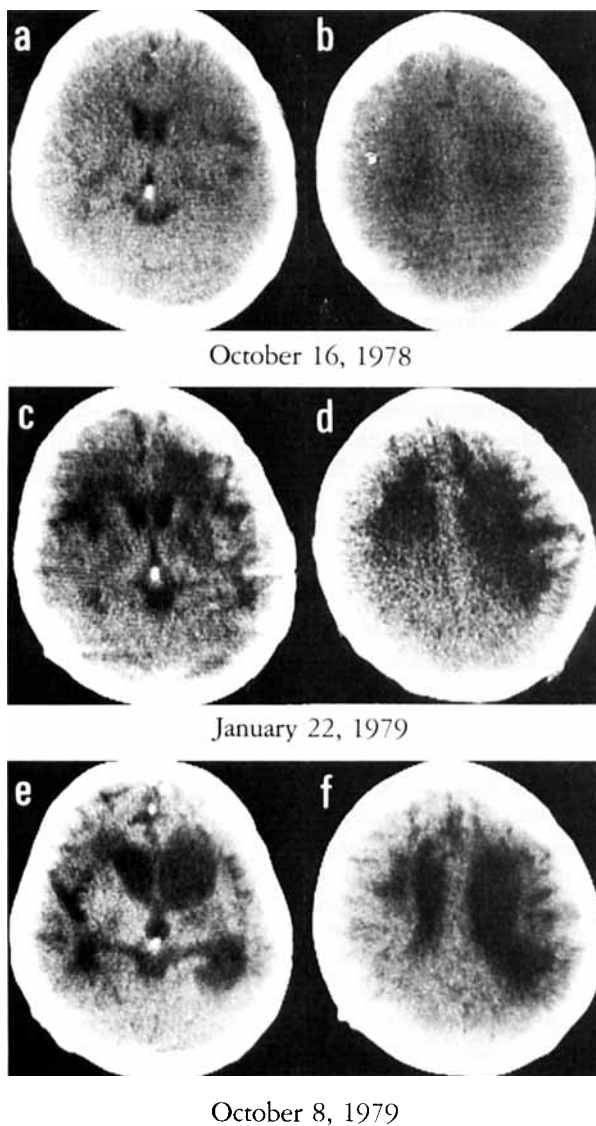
Evolution of CT scan findings. Scans were obtained on the dates specified. Montage presents the left hemisphere on the right side of the figure. The first scan shows only a small peripheral area of decreased density in the posterolateral frontal region (a, b). Three months later, in January, the demyelinated hypodense areas are now extensive (c, d). Subsequently, atrophy with sulcal and ventricular enlargement developed in the areas of previous demyelination (e, f).
